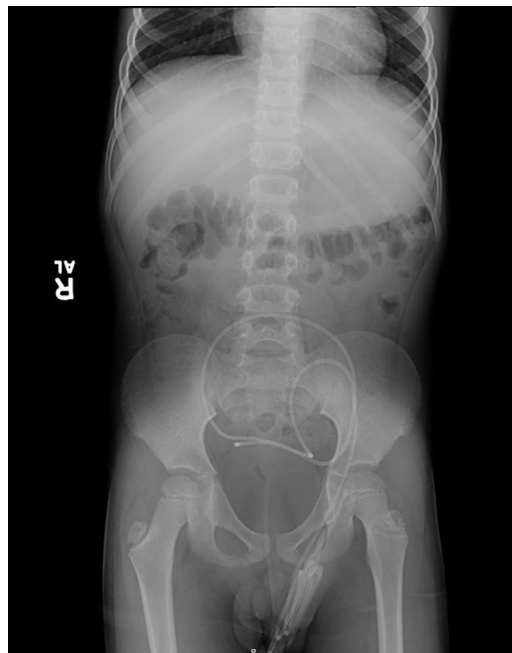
Abdominal radiograph showing the fractured shunt catheter herniating into the left scrotum.
